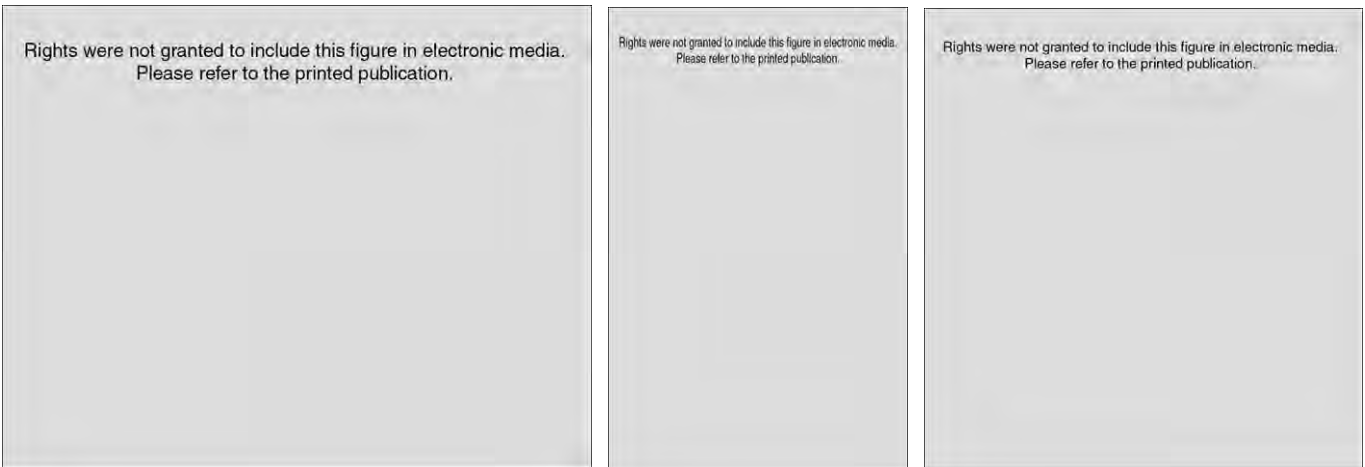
The utility of contrast imaging of gastrointestinal lymphomas. A, Double-contrast radiography showing a severely constricted lesion in the ileum that was subsequently diagnosed as MALT lymphoma. B, Double-contrast radiography revealing an ulcerative lesion with mucosal destruction in the terminal ileum, later diagnosed as diffuse large B-cell lymphoma. C, Small bowel lymphoma complicating celiac disease with a mass in the right iliac fossa. (A and B, From Nakamura S, Matsumoto T, Takeshita M, et al: A clinicopathologic study of primary small intestine lymphoma: Prognostic significance of mucosa-associated lymphoid tissue–derived lymphoma. *Cancer* 88:286-294, 2000; C, from Ciclitira PJ: Celiac disease. In Yamada T [ed]: Atlas of Gastroenterology. Philadelphia, Lippincott, Williams & Wilkins, 2003, pp 331-340.)
